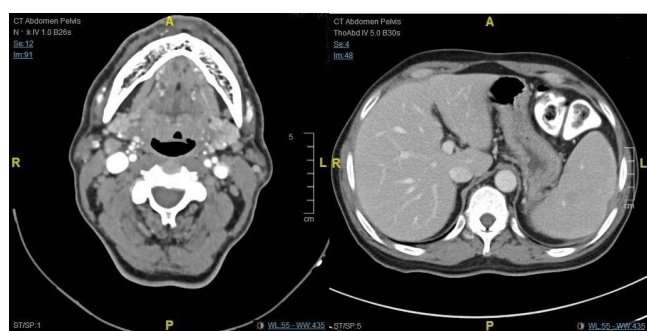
(A) Contrast CT scan of the neck showed multiple enhancing and enlarged cervical lymph nodes at level Ib and level II. (B) Contrast CT scan of the abdomen showed multiple subcentimeter lymph nodes at peripancreatic and para-aortic regions with splenomegaly.
